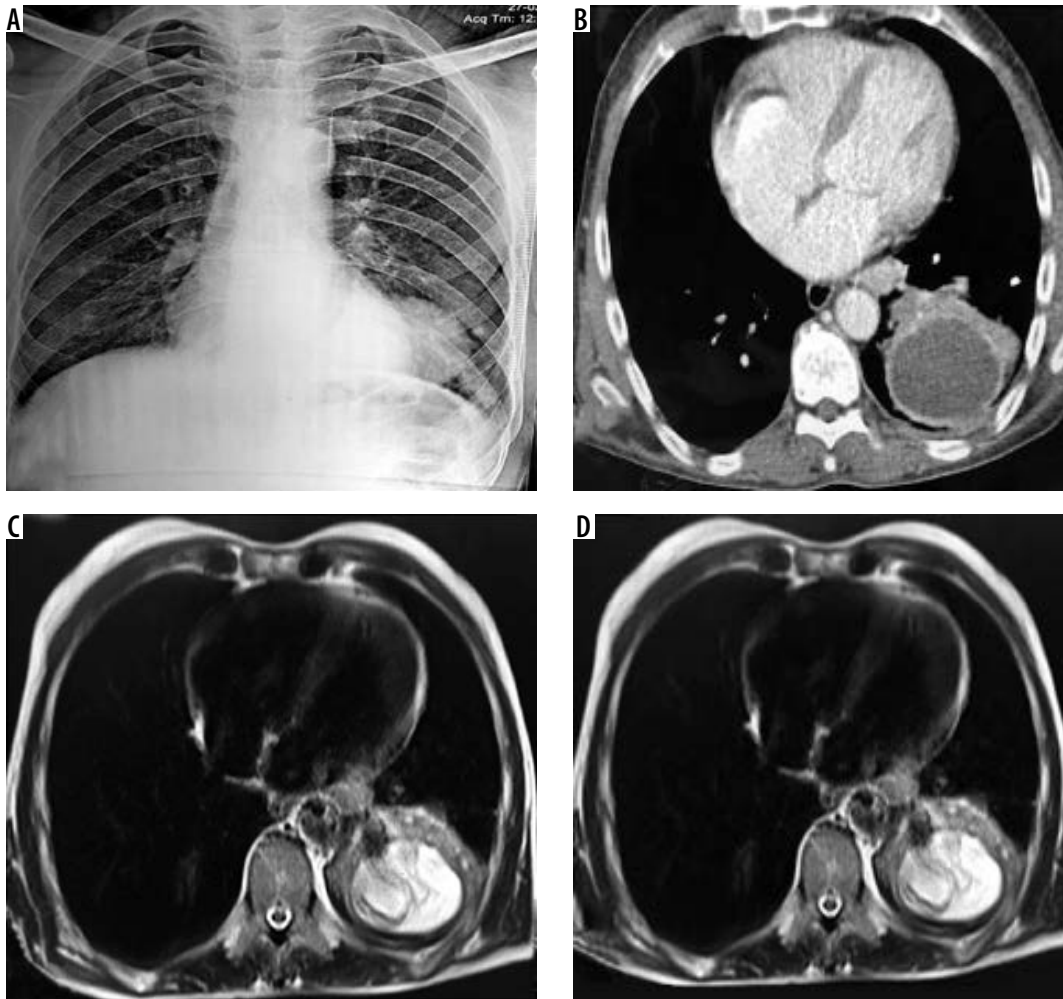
Frontal radiograph of chest (A) shows a homogenous round opacity in left lower lobe. Corresponding axial computed tomography image (B) shows round cystic lesion with slightly irregular wall and surrounding consolidation. Corresponding T2-W axial images (C and D) show hyperintense cyst with wavy floating hypointense membrane within the cyst
